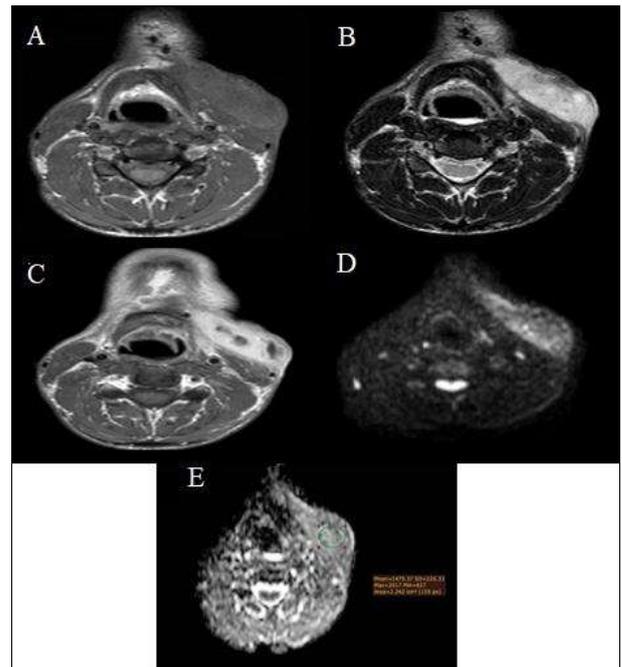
MRI findings: (A) Thick walled fluid collection at the left side of the neck that appears low signal intensity at T₁WI, (B) high signal intensity at T₂WI, (C) with thick marginal enhancement at T₁WI, (D) seen restricted on DWI, (E) with ADC value estimated to be $1.475 \times 10^{-3} \text{ mm}^2/\text{s}$
